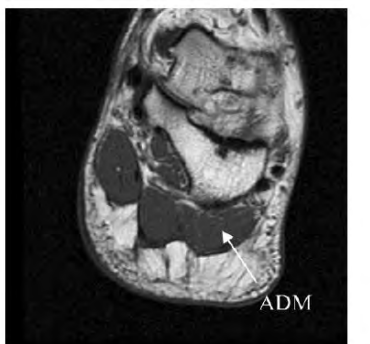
Coronal T1-weighted image demonstrating normal abductor digiti minimi (ADM) muscle
